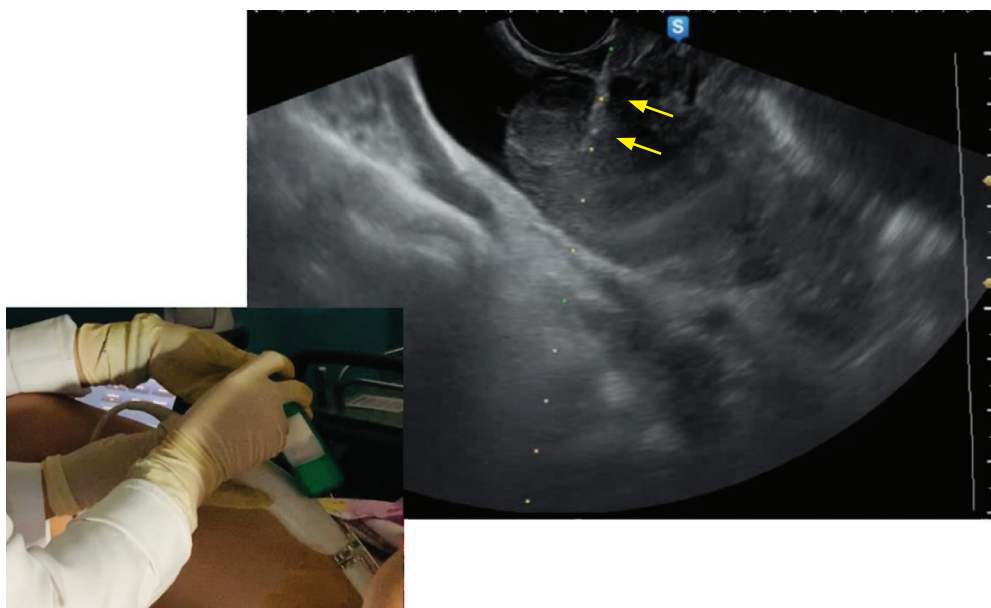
Tru-cut biopsy of the right ovarian mass done under transvaginal ultrasound guidance. The tru-cut needle is inserted through the needle guide attached to the transvaginal probe. After securing placement of the needle within the tumor, the biopsy gun is fired. The biopsy needle (yellow arrows) is shown penetrating into the lesion. The dotted line represents the track of the needle.
